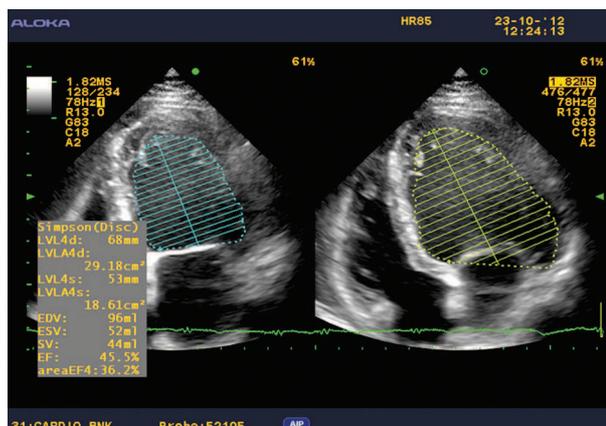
Simpson echocardiographic patterns
